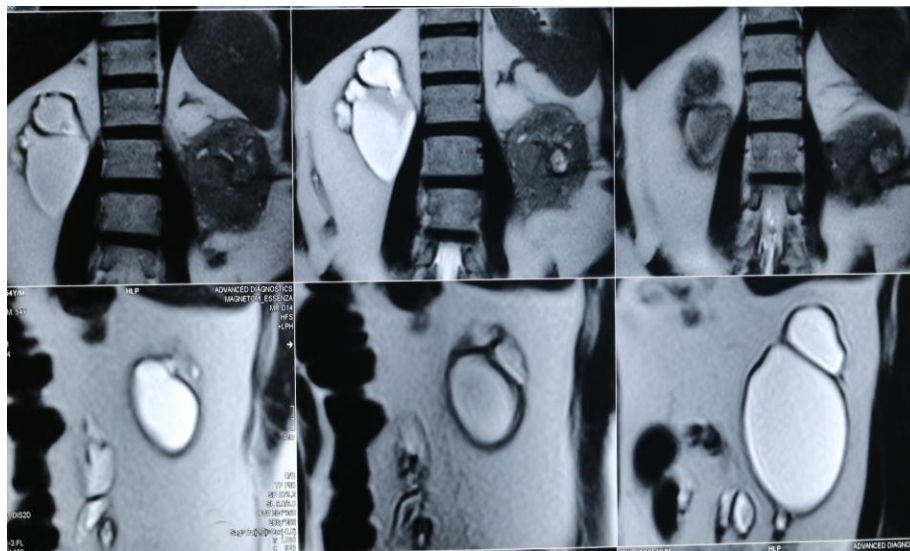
MRI of the abdomen showing a grossly hydronephrotic left renal pelvis with a resected small right partially functional kidney
